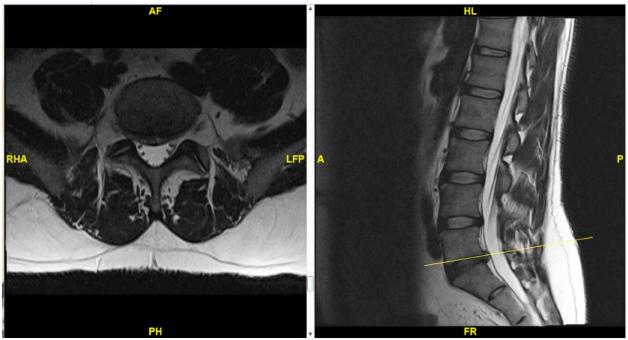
Axial and sagittal T2-weighted images demonstrating loss of disc height and hydration at L5/S1 with a right posterolateral broad-based disc bulge adjacent to the right S1 spinal nerve without nerve compression.
